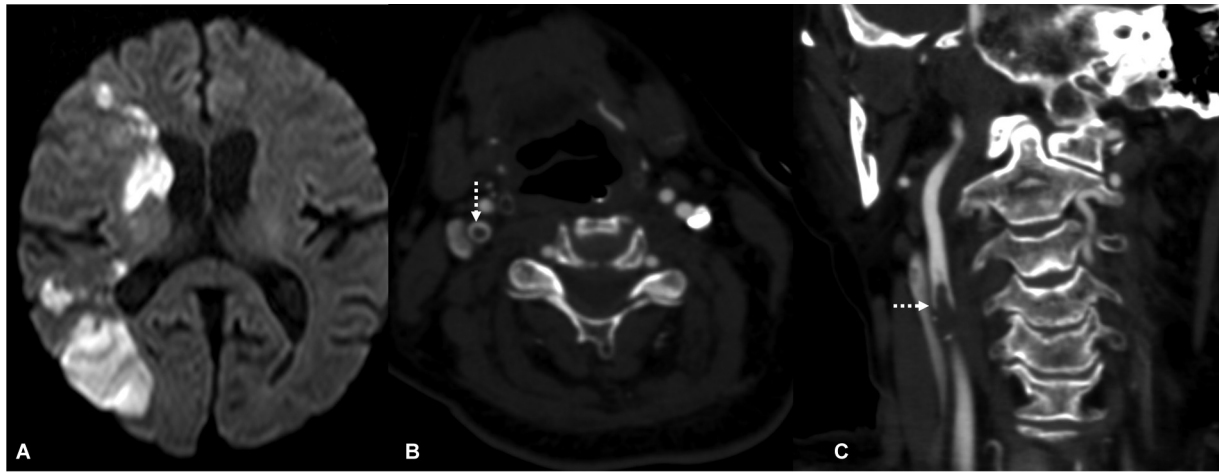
Free-floating thrombus in coronavirus disease 2019 (COVID-19) infection: A 55-year-old male, COVID-19 positive on 10th day of his illness, developed sudden weakness of left side of the body. The axial diffusion-weighted image (A) shows patchy diffusion restricting acute infarct in right middle cerebral artery territory and watershed zone. The axial (B) and coronal (C) images of computed tomographic angiogram of neck vessel reveal a free-floating thrombus with plaque at right carotid bulb extending into the proximal internal carotid artery (dashed white arrows). These free-floating thrombi are frequent association with COVID-19 infection.
